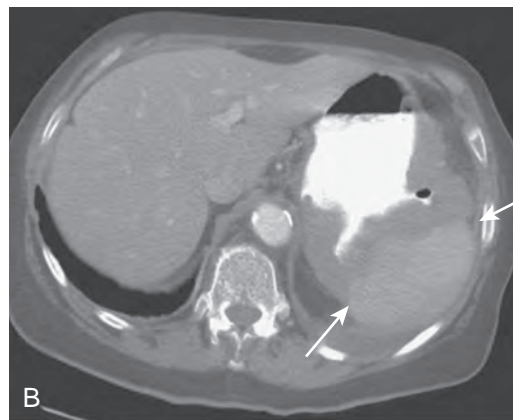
Spread of gastric cancer into the gastrohepatic ligament. Coronal reformatted CT image shows tumor invasion of the gastrohepatic ligament (black arrow). Peritoneal tumor implants (white arrows) are identified.
